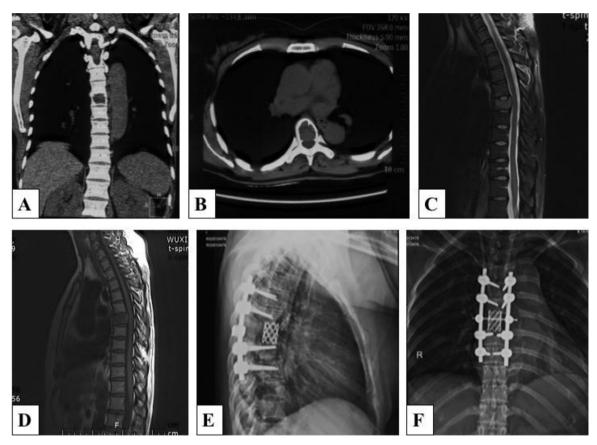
A, B: Preoperative CT revealed obvious bone destruction of the vertebra with intact posterior elements. C, D: Preoperative MRI indicated a compressed fracture of the vertebra and slight compression of the dura. E, F: The postoperative X-ray after TES.
